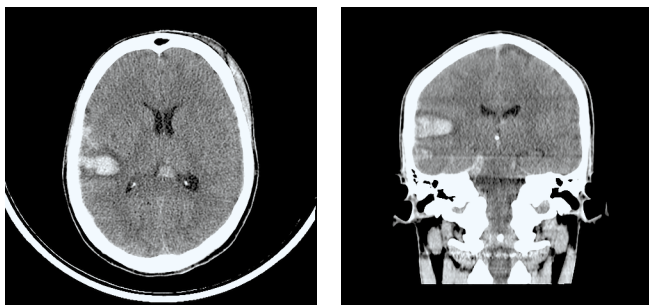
CT scan showing right parietal contusion, quadrigeminal cistern and fourth ventricular haemorrhage.
